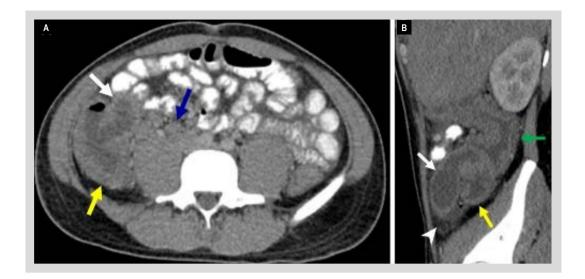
Axial (Panel A) and sagital (Panel B) IV contrast-enhanced CT images through the abdomen show bowel wall thickening and enhancement of the distal ileum (yellow arrows), cecum (white arrows), and ascending colon (green arrow). Mesenteric adenopathy (blue arrow) and inflammation (white arrowhead) also are noted.
